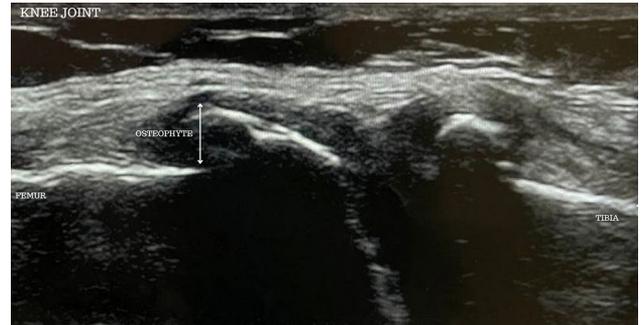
Appearance of osteophytes in the musculoskeletal ultrasound of osteoarthritis knee.
